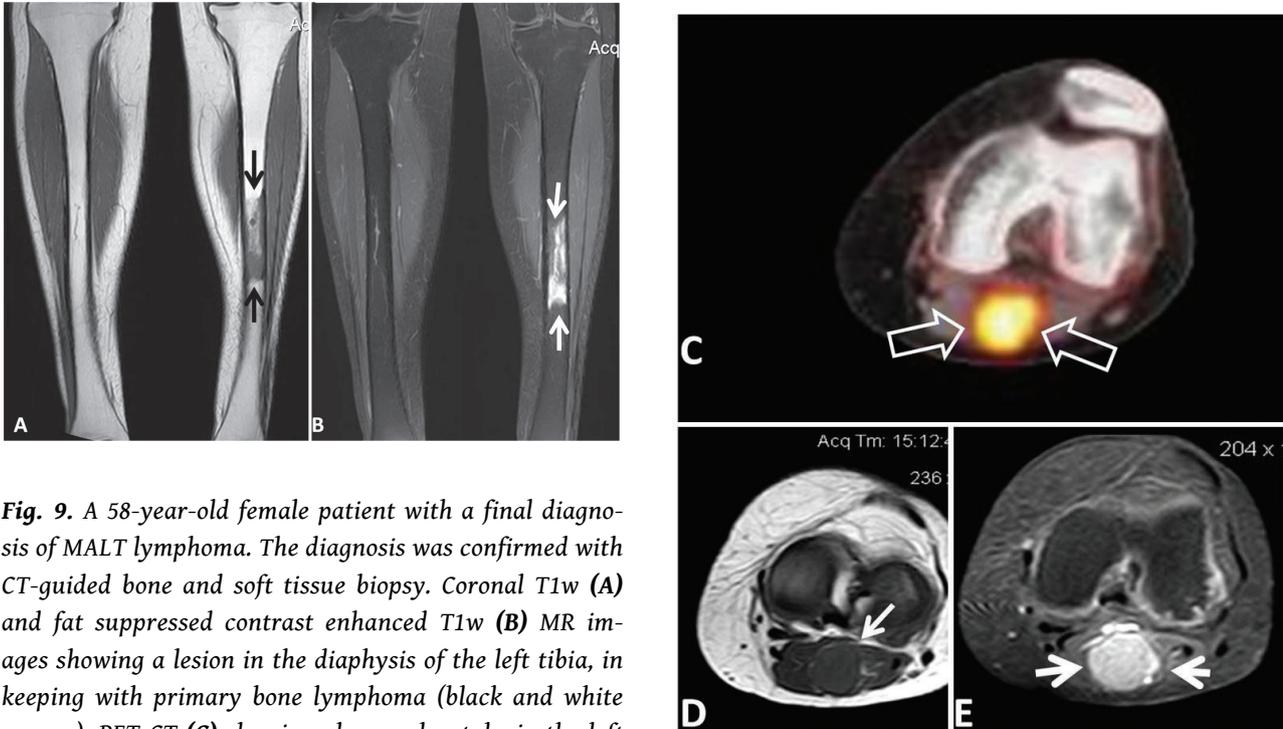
A 58-year-old female patient with a final diagnosis of MALT lymphoma. The diagnosis was confirmed with CT-guided bone and soft tissue biopsy. Coronal T1w (A) and fat suppressed contrast enhanced T1w (B) MR images showing a lesion in the diaphysis of the left tibia, in keeping with primary bone lymphoma (black and white arrows). PET-CT (C) showing abnormal uptake in the left popliteal fossa in the absence of any symptoms in this area (white open arrows). Axial T1w MR image (D) shows a iso- to hypointense lesion (white arrow) which is avidly enhancing following GD-DTPA intravascular injection (white arrows in E).
